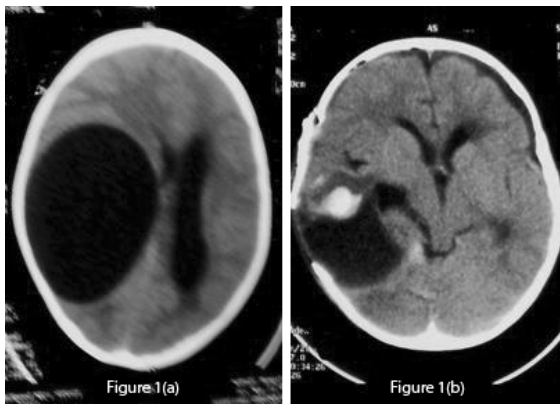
(a): Pre-operative unenhanced CT scan which shows a large CSF density cystic lesion on the right side causing mass effect and midline shift to the left. There is no peri-lesional oedema. Fig 1 (b): Post-operative CT scan of the lesion shows a large void which can lead to dangerous collapse. Mild haematoma is also seen.
